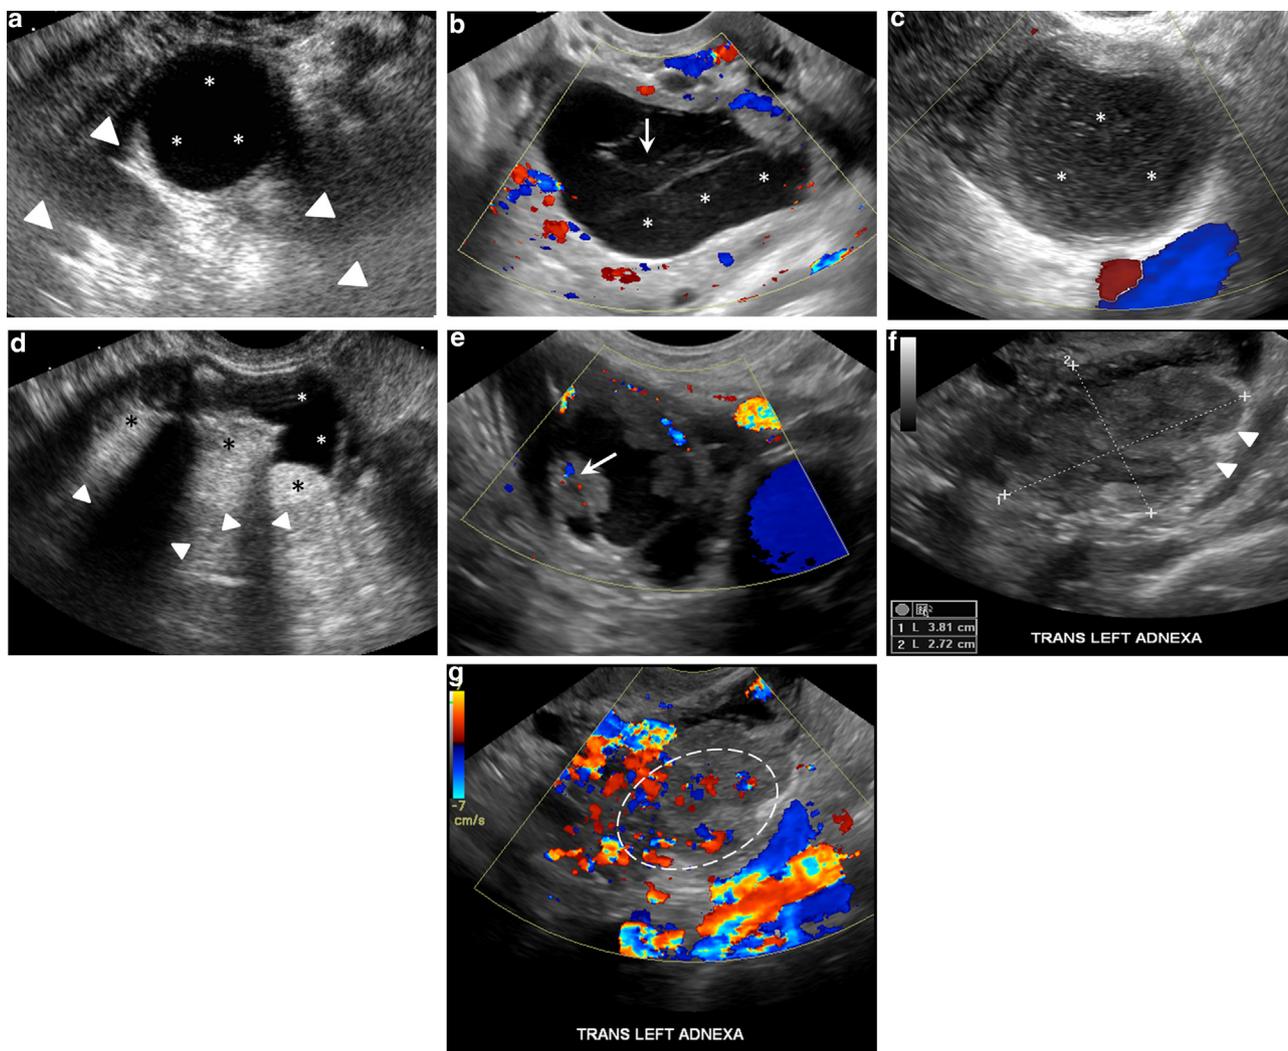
a: Gray scale and color Doppler ultrasound image of a classic simple cyst, with anechoic fluid (asterisks) and increased through transmission posteriorly (arrowheads); b: Gray scale and color Doppler ultrasound image of a classic hemorrhagic cyst, with internal debris (asterisks), retractile clot (arrow) and no internal color Doppler blood flow; c: Gray scale and color Doppler ultrasound image of a classic endometrioma, with ground glass or homogeneous low-level echoes throughout the lesion (asterisks); d: Gray scale and color Doppler ultrasound image of a classic dermoid, with simple fluid (white asterisks) and echogenic components (black asterisks) with associated acoustic shadowing (arrowheads); e: Gray scale and color Doppler ultrasound image of a partially cystic left adnexal lesion with internal nodules, one of which exhibits color Doppler flow (arrow). On pathologic evaluation, this was a borderline serous tumor; f: Gray scale and color Doppler ultrasound image of a solid left adnexal lesion with lobular borders (arrowheads); g: Gray scale and color Doppler ultrasound image of the same solid left adnexal lesion as pictured in (f), with significant internal color Doppler flow (dashed oval). On pathologic evaluation, this was a high grade serous tumor.
